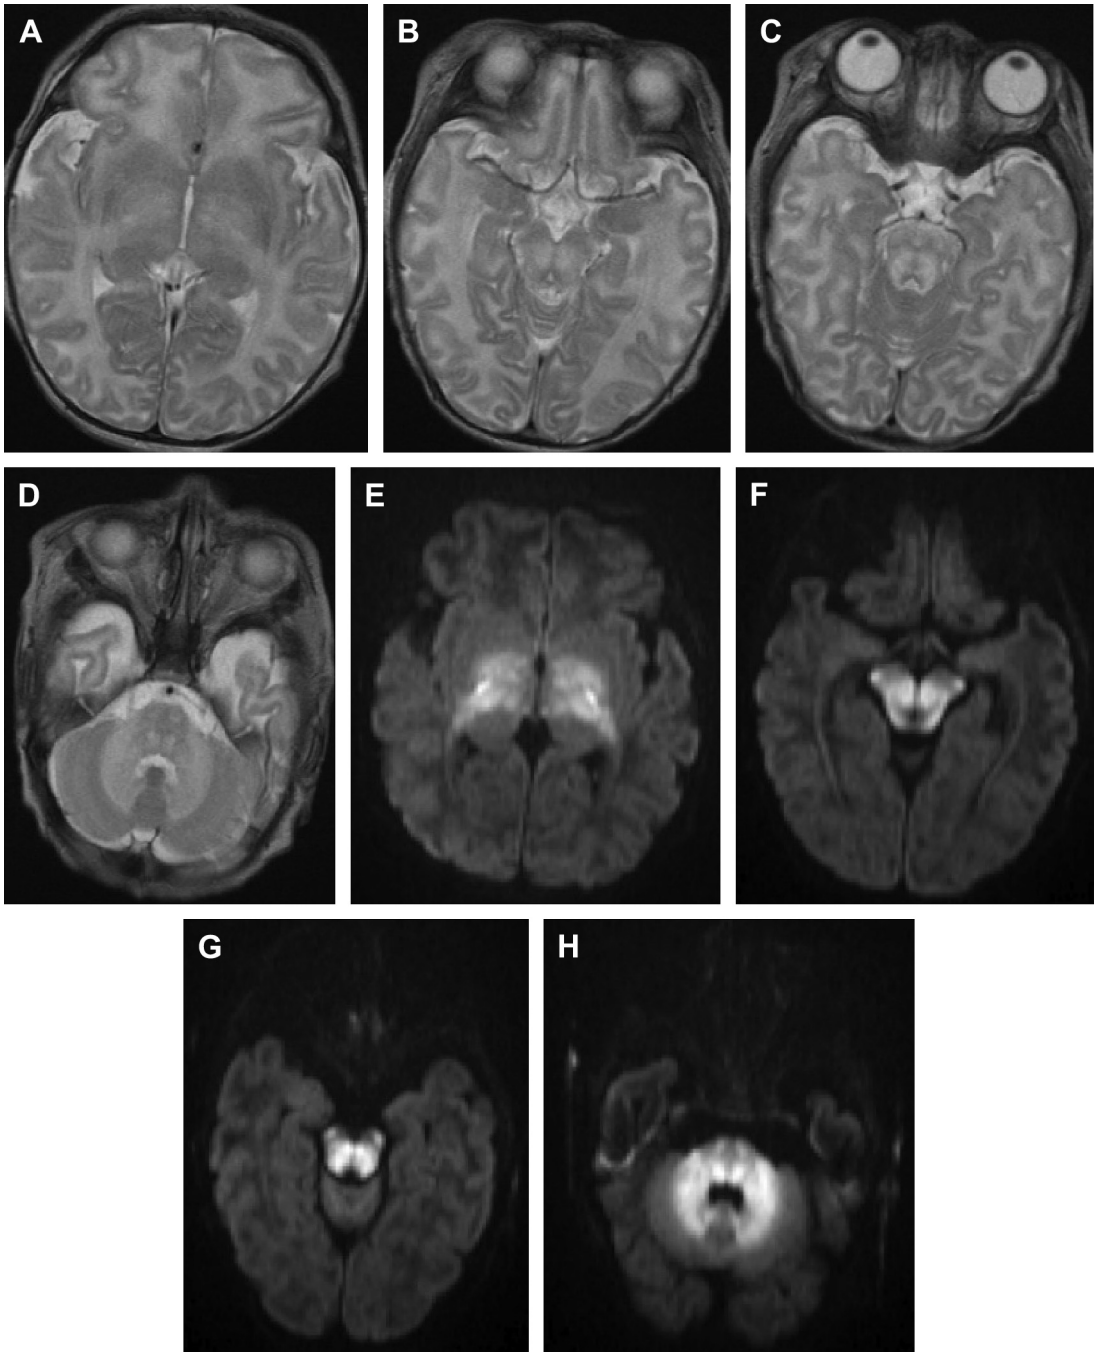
Eleven-day-old infant with newly diagnosed maple syrup urine disease. Axial T2-weighted (A–D) and diffusion-weighted trace images (E–H) demonstrate signal abnormality and restricted diffusion in sites of normal neonatal brain myelination: posterior limbs of the internal capsule (A, E), brainstem corticospinal tracts (B–D, F–H), dorsal brainstem (B, C, F, G), and the cerebellar peduncles (D, H). The restricted diffusion is typical for patients imaged in acute decompensation.
